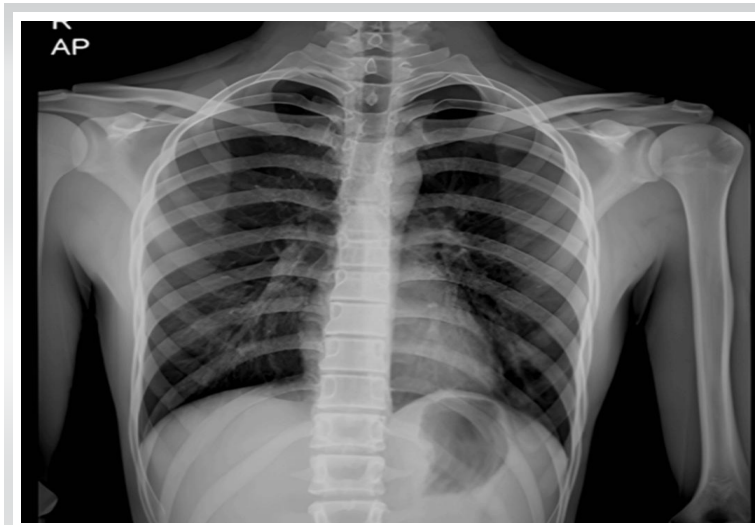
Follow-up radiograph at 12 weeks demonstrating satisfactory healing with callus formation in both clavicles.
